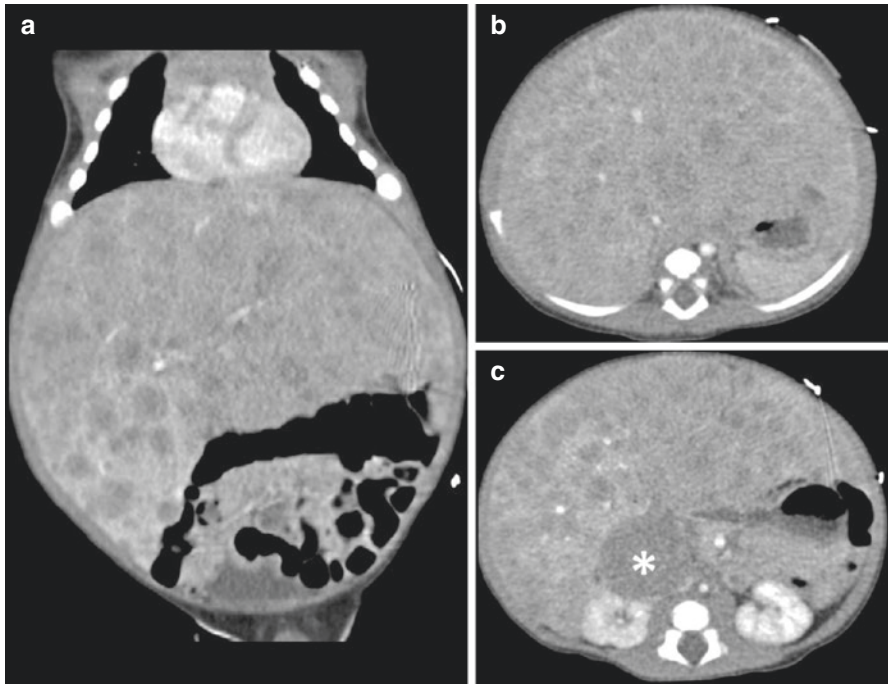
A 2-month-old boy with metastatic abdominal neuroblastoma (INSS stage 4S, INRGSS MS). Contrast-enhanced CT-scan coronal (a) and transverse (b, c) views. The primary tumour arises from the right adrenal gland and demonstrates low density and limited enhancement (asterisk). The liver is dramatically enlarged and diffusely invaded by multiple metastases appearing as low-density nodules compared to normal parenchyma on portal phase
